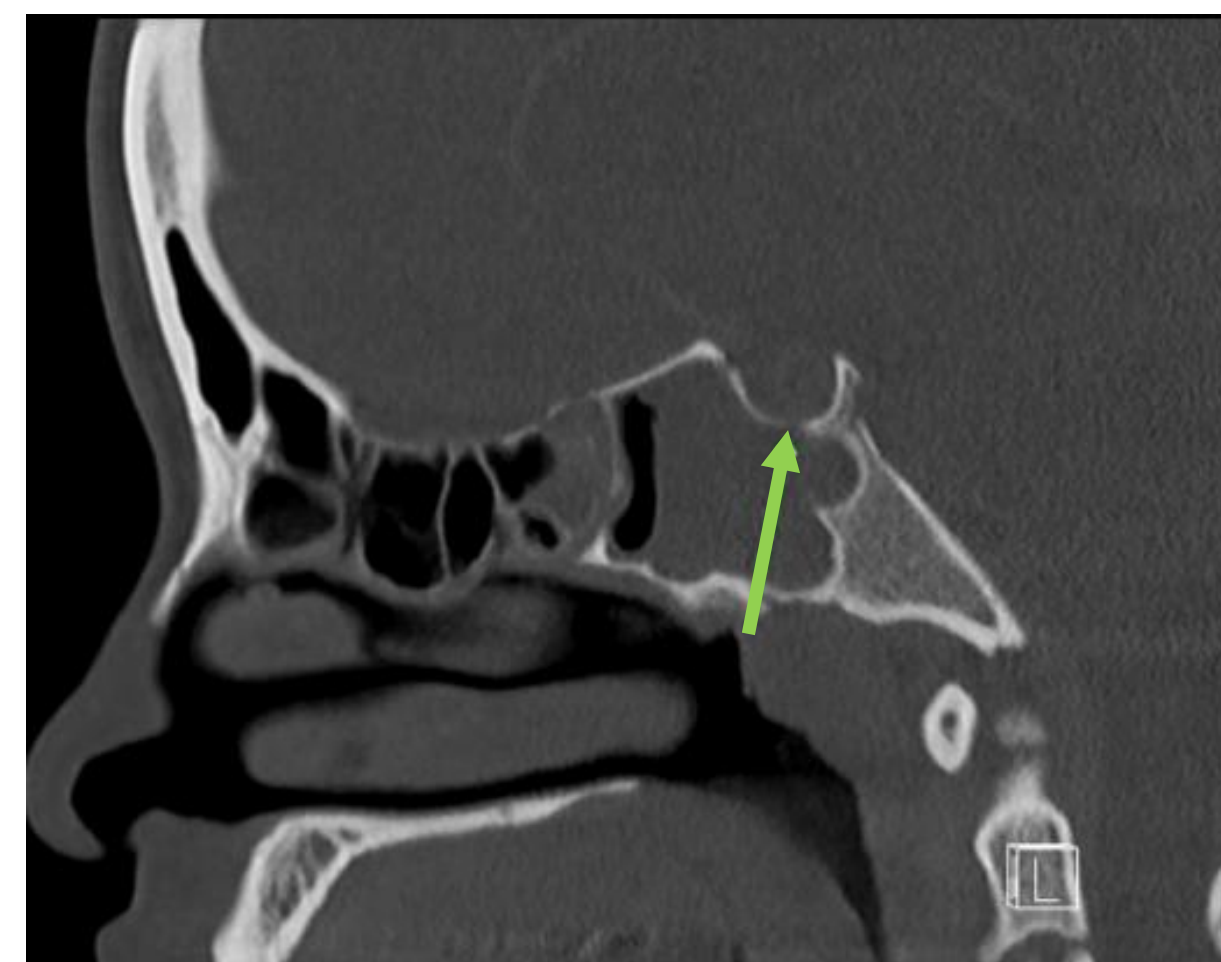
CT Sinus with contrast, sagittal cut, posterior ethmoid and sphenoid sinus disease with bony dehiscence along superior wall of sphenoid sinus/anterior sella (arrow)
